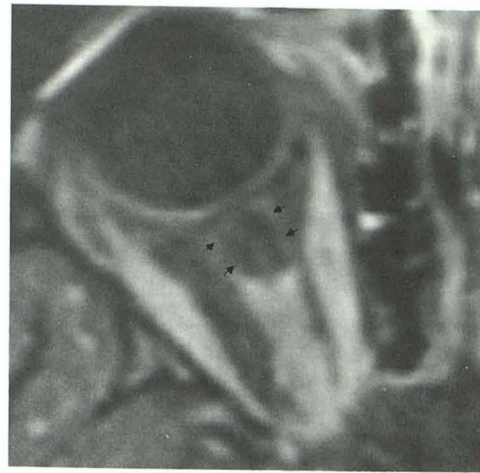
T1-weighted (600/20/2) post-gadolinium 3-mm axial scan (obtained with fat suppression) demonstrates meningioma of the posterior two thirds of the right optic nerve sheath. Anterior to the meningioma there is dilation of the optic nerve sheath (arrows). In the central portion of the dilated nerve sheath is an atrophic optic nerve.
